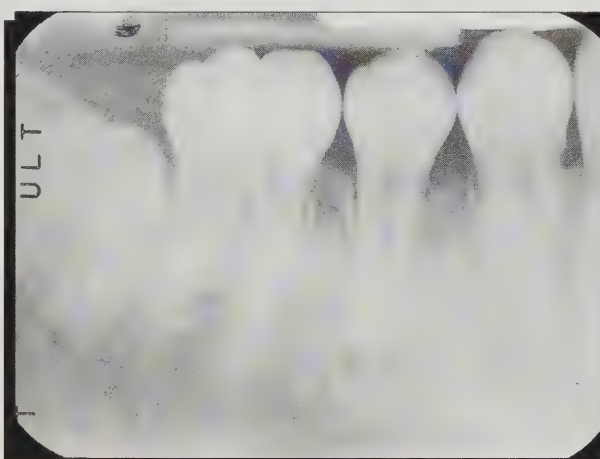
(Case Three): A periapical radiograph of the mandibular right second bicuspid shows an evagination extending from the occlusal aspect of the tooth. Note the immaturity of the apex.
